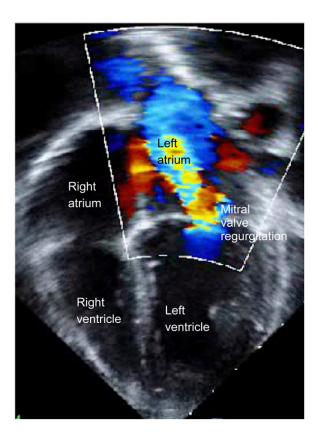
Echocardiogram with color Doppler showing severe mitral regurgitation.
